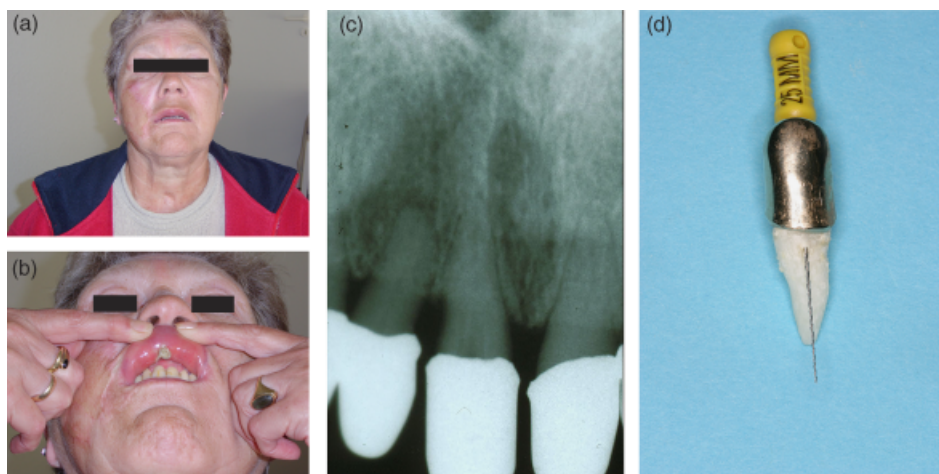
(a) Swelling of the patient's lip following extrusion of sodium hypochlorite through a perforation of the root of the first right maxillary incisor. (b) Ulcer at the inner side of the upper lip 6 weeks after the incident. (c) Radiograph of the maxillary right first incisor. (d) The instrument extends through the buccal perforation of the root. Case courtesy of Dr. Sennhenn-Kirchner.
